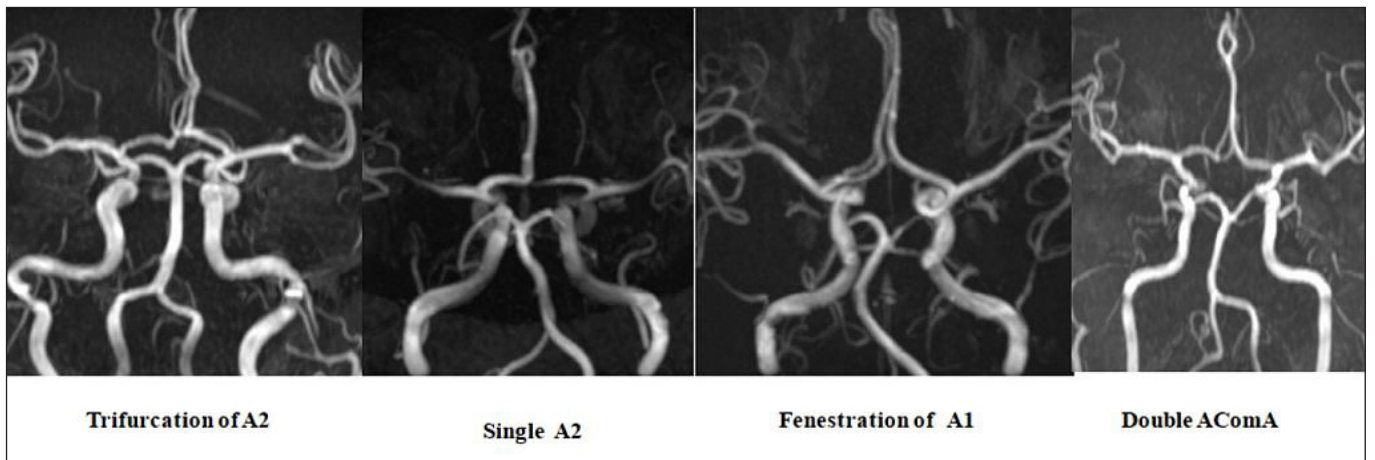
Time-of-flight magnetic resonance image of the of other rare variants.
